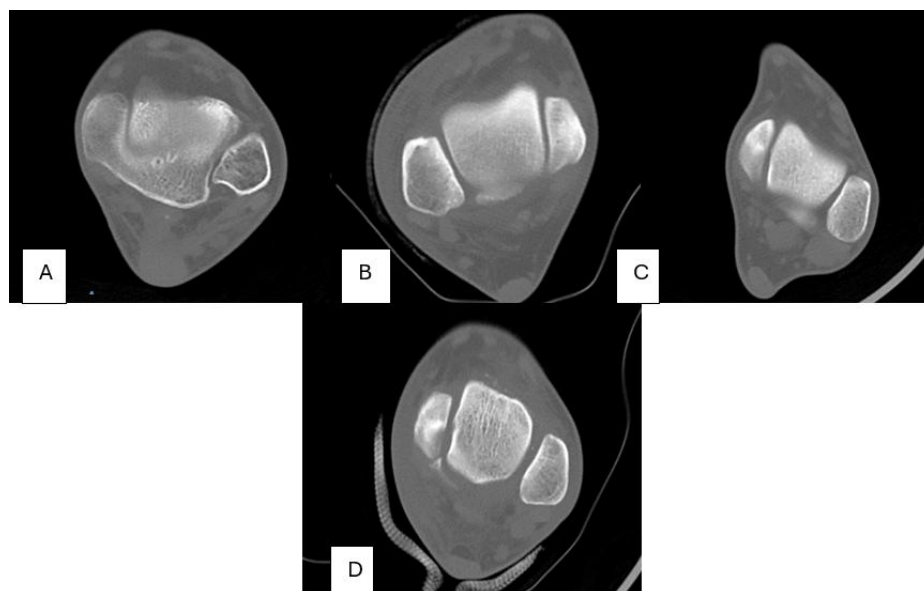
Axial CT scans depicting images of the four most seen fibular groove. A: Concave, B: Irregular, C: Flat, D: Convex.
